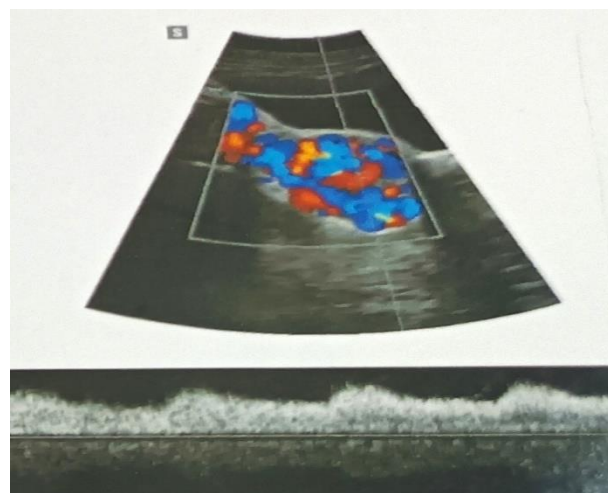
Color Doppler image shows dilated vascular channels with increased vascularity in right half of uterus and blood flow was bidirectional.
